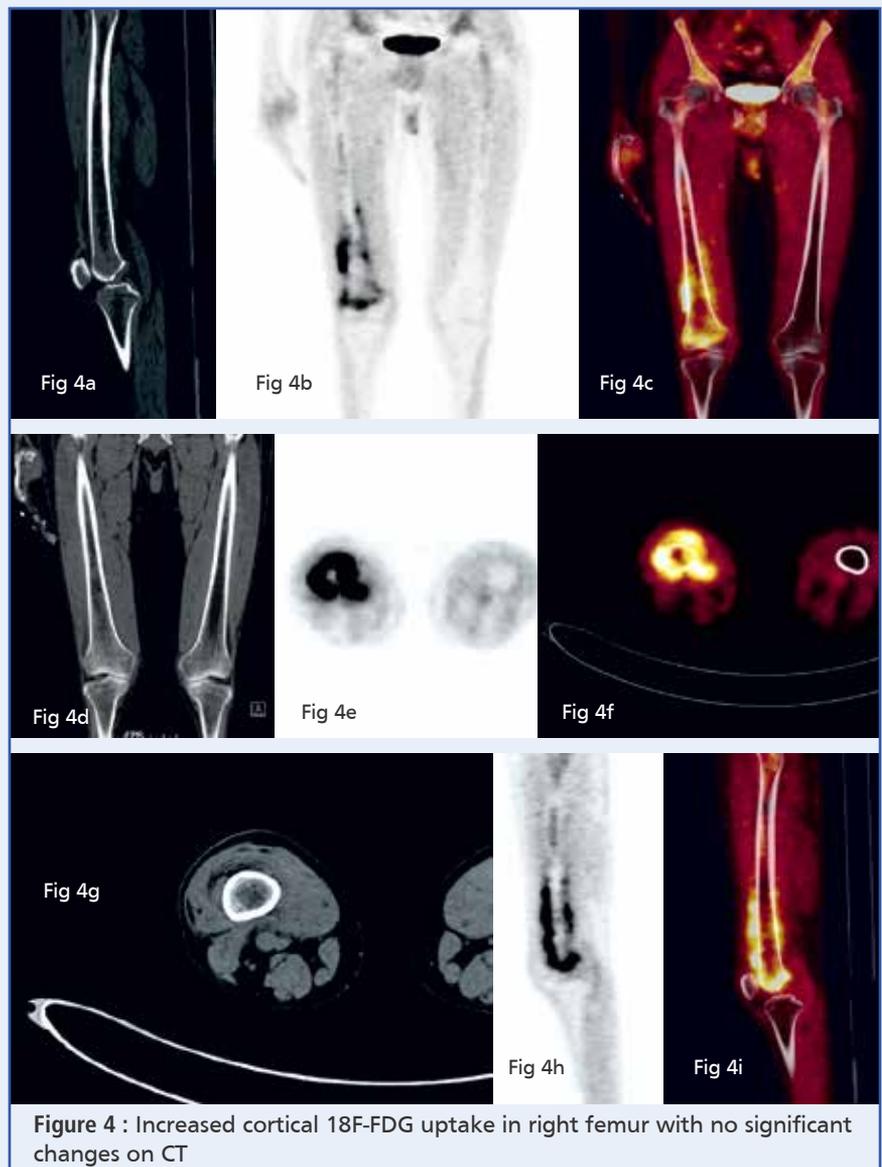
Increased cortical 18F-FDG uptake in right femur with no significant changes on CT
